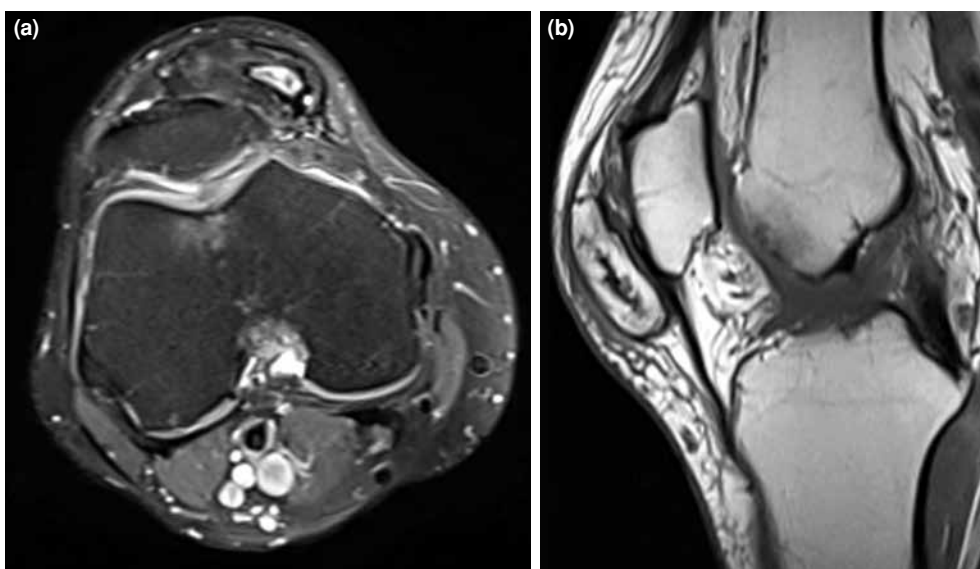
Magnetic resonance imaging shows (a) T₂ axial section and (b) T₁ sagittal section of cortex on anterior of patella.
